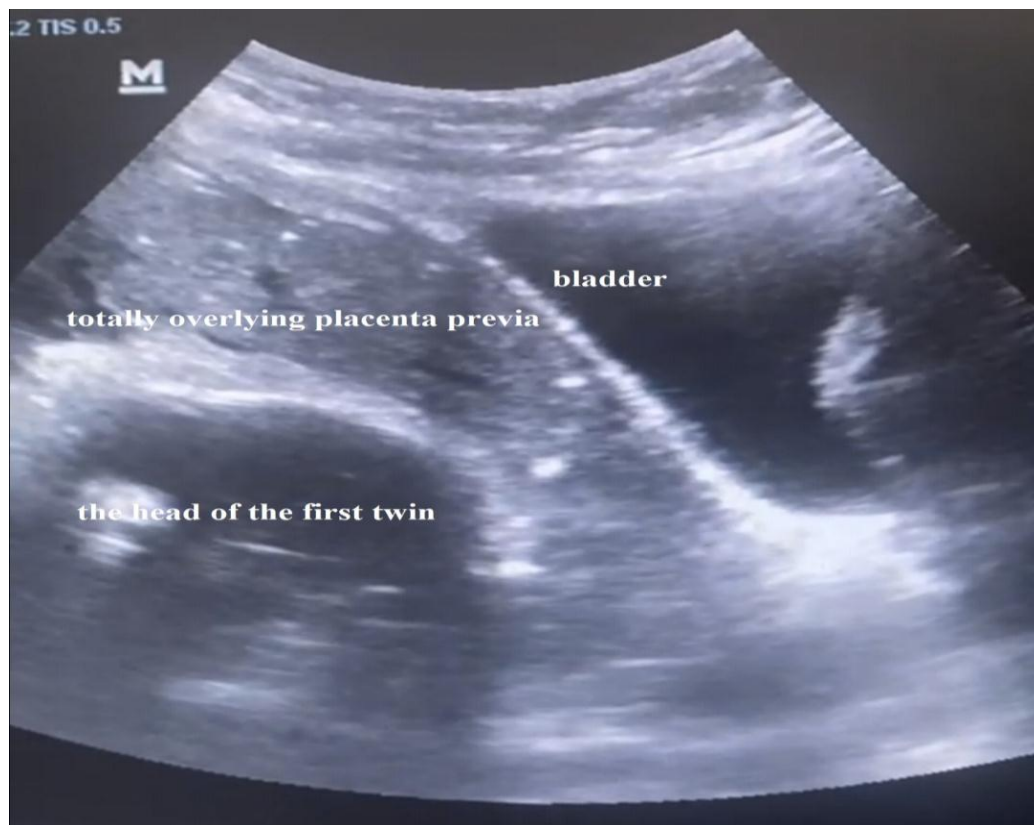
Totally overlying placenta previa on endovaginal ultrasound, first twin in cephalic presentation.
